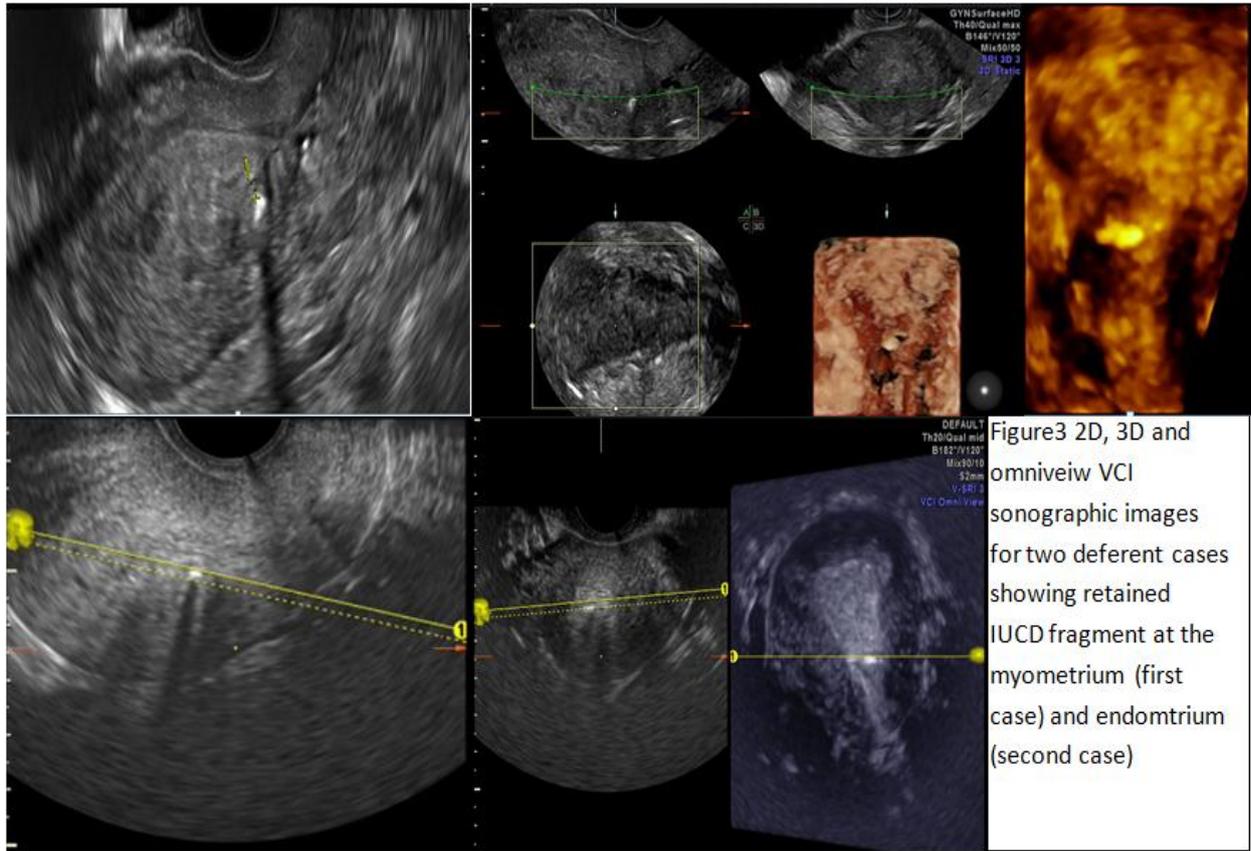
2D, 3D and omniview VCI sonographic images for two defferent cases showing retained IUCD fragment at the myometrium (first case) and endomtrium (second case)
